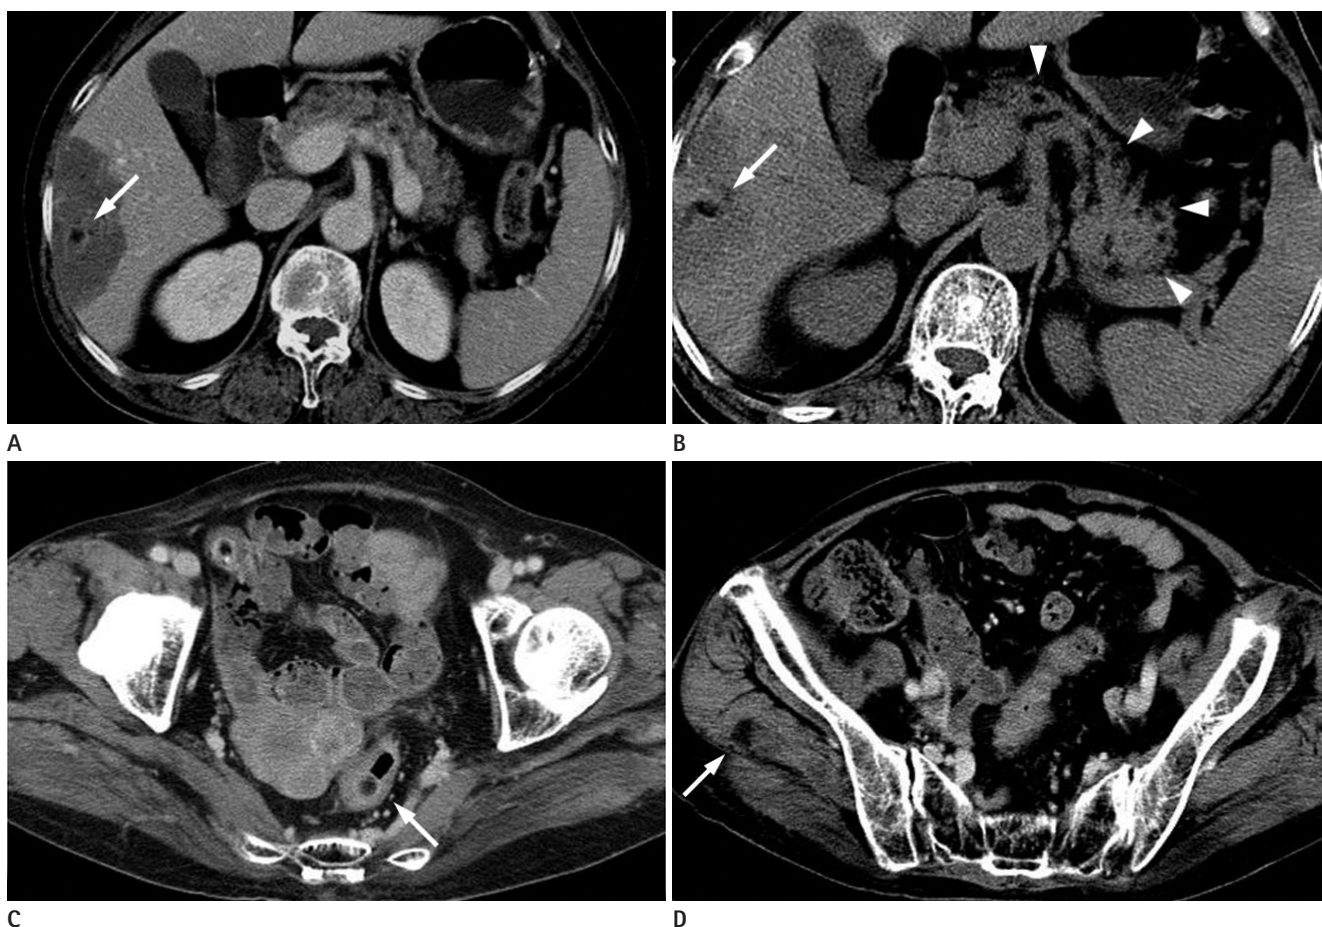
Contrast enhanced CT scans of abdomen.
